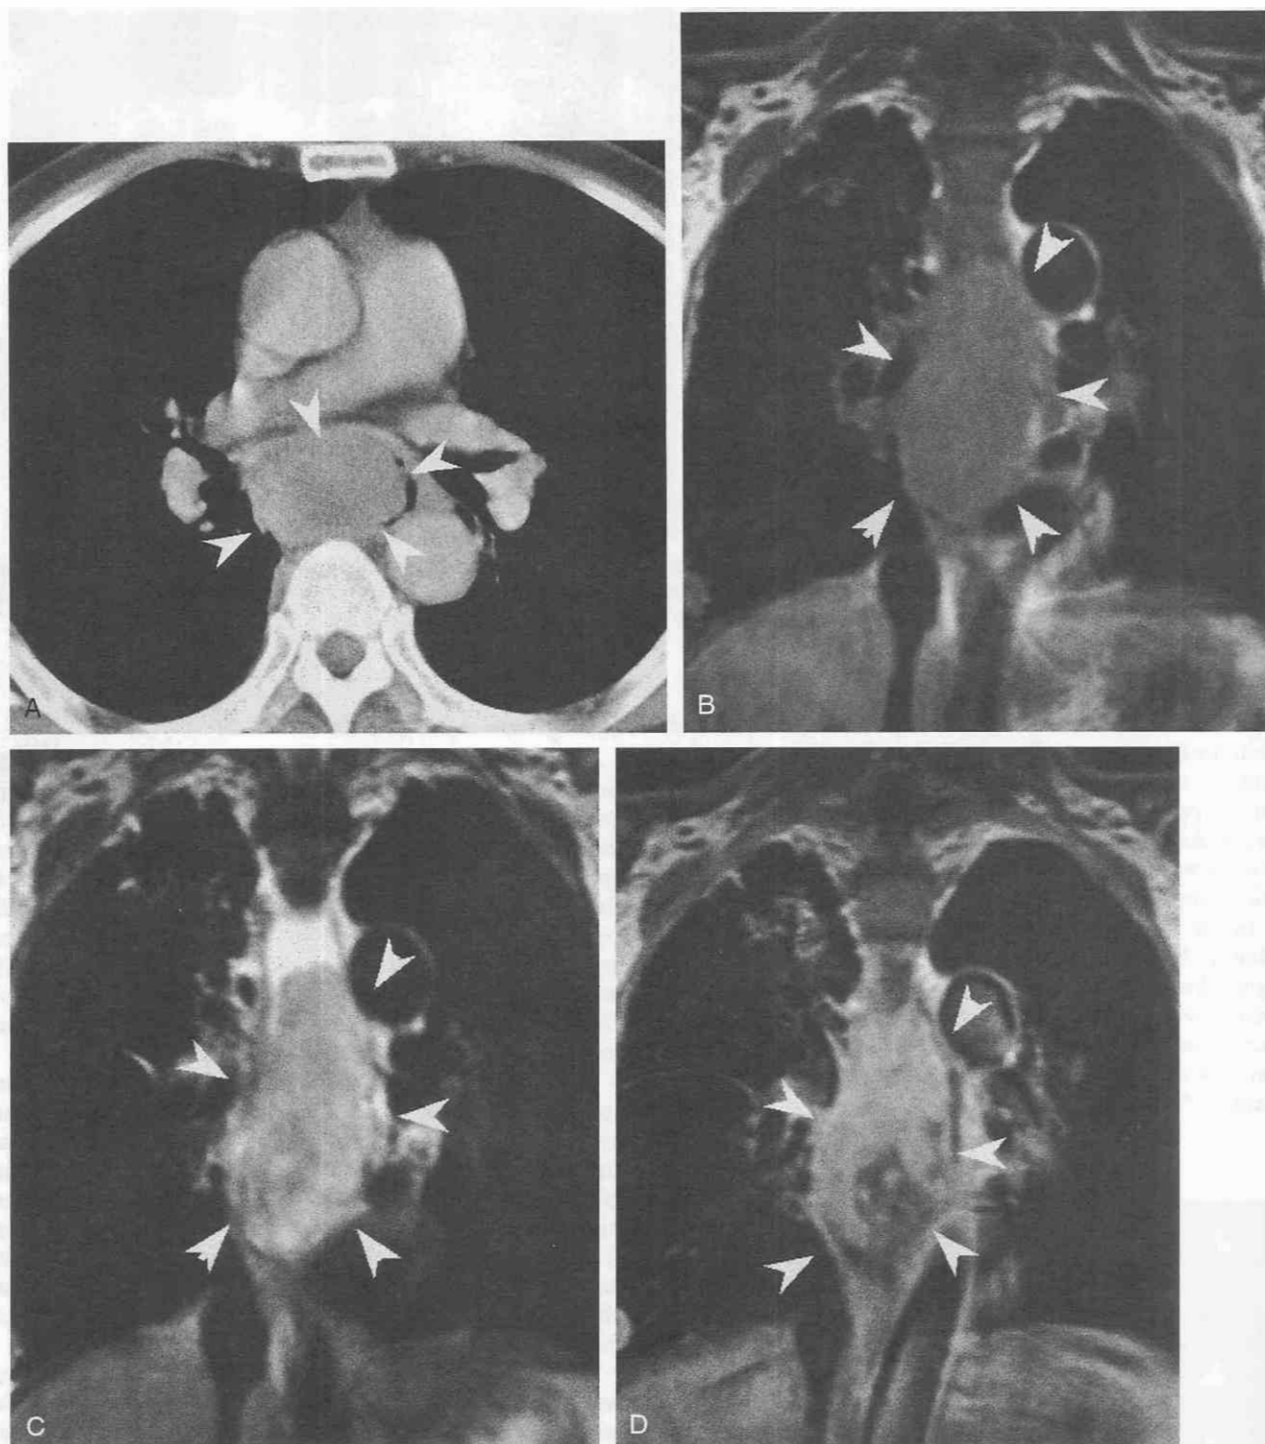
Malignant spindle cell tumor of the esophagus. *A*, CT scan shows a giant polypoid intraluminal mass (arrowheads) with homogeneous soft tissue attenuation. This lesion is hypointense on T1-weighted image (*B*) and heterogeneously hyperintense on T2-weighted image (*C*). After administration of gadolinium-DTPA (*D*), the lesion (arrowheads) shows heterogeneous considerable enhancement. The lesion does not cause esophageal obstruction despite its large size.
